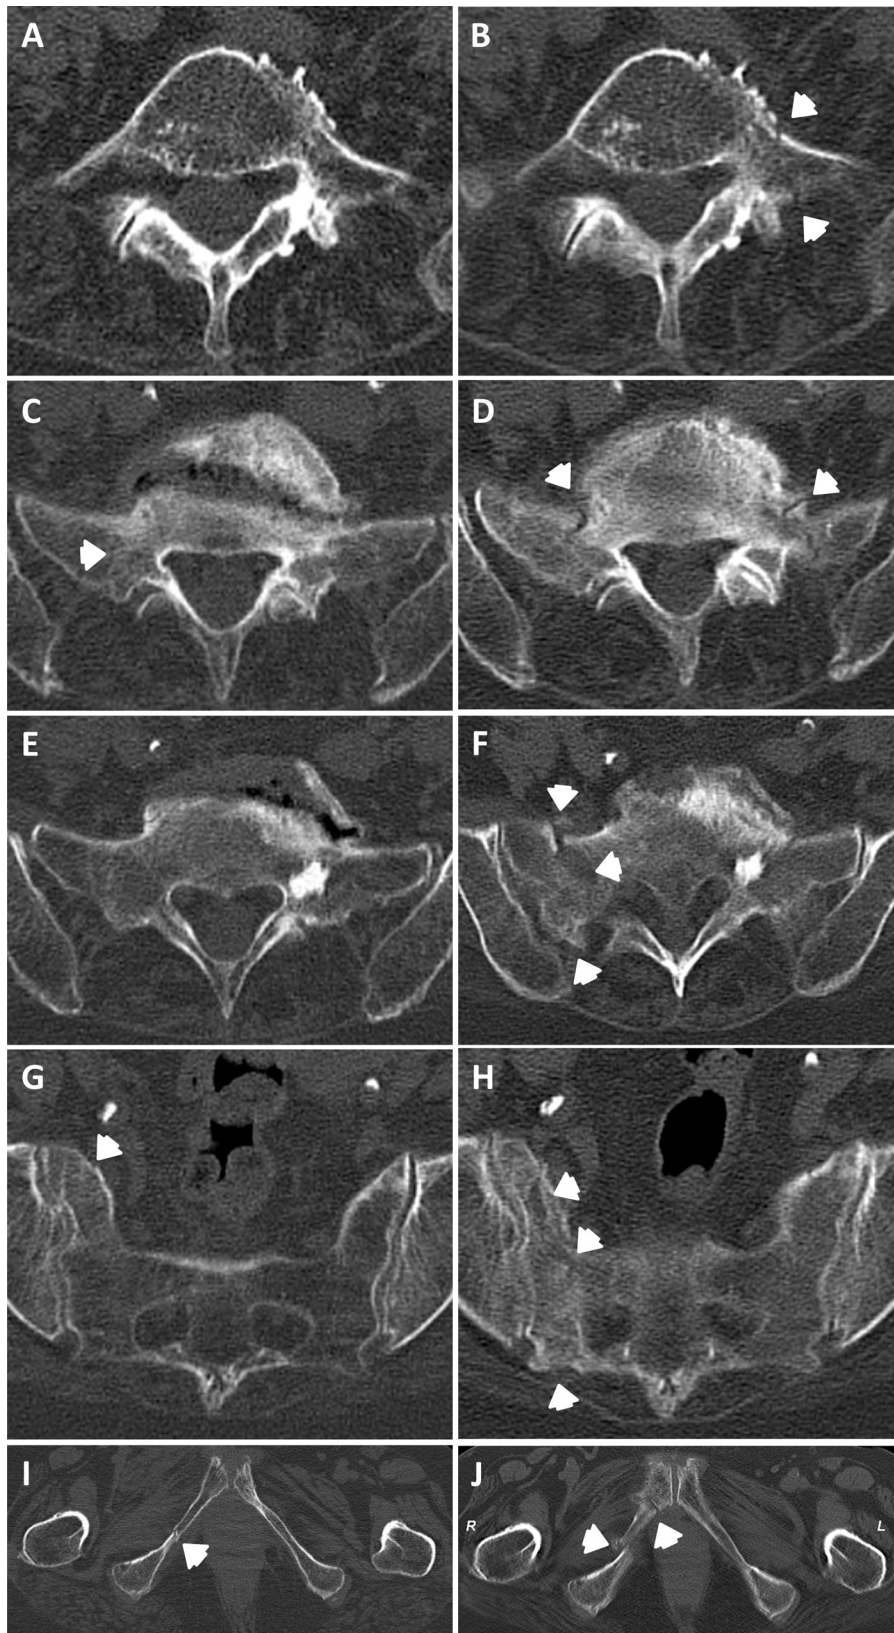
Natural course of a creeping collapse of the pelvis during conservative treatment of a fragility fracture. CT scan examinations were performed in an 82 years old woman after a fall from a standing position (A, C, E, G, I) and four weeks later (B, D, F, H, J). The latter CT scan was performed due to a persisting severe pain and inability to get out of bed. Fracture lines can be hardly identified in the initial CT-scan (arrows), whereas four weeks later, additional fracture lines and fracture line widening become evident in the latter CT scan (arrows).
